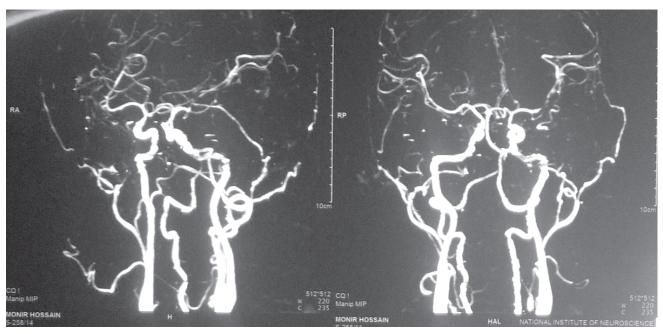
CTA of Brain showing absence of AVM nidus following surgery
